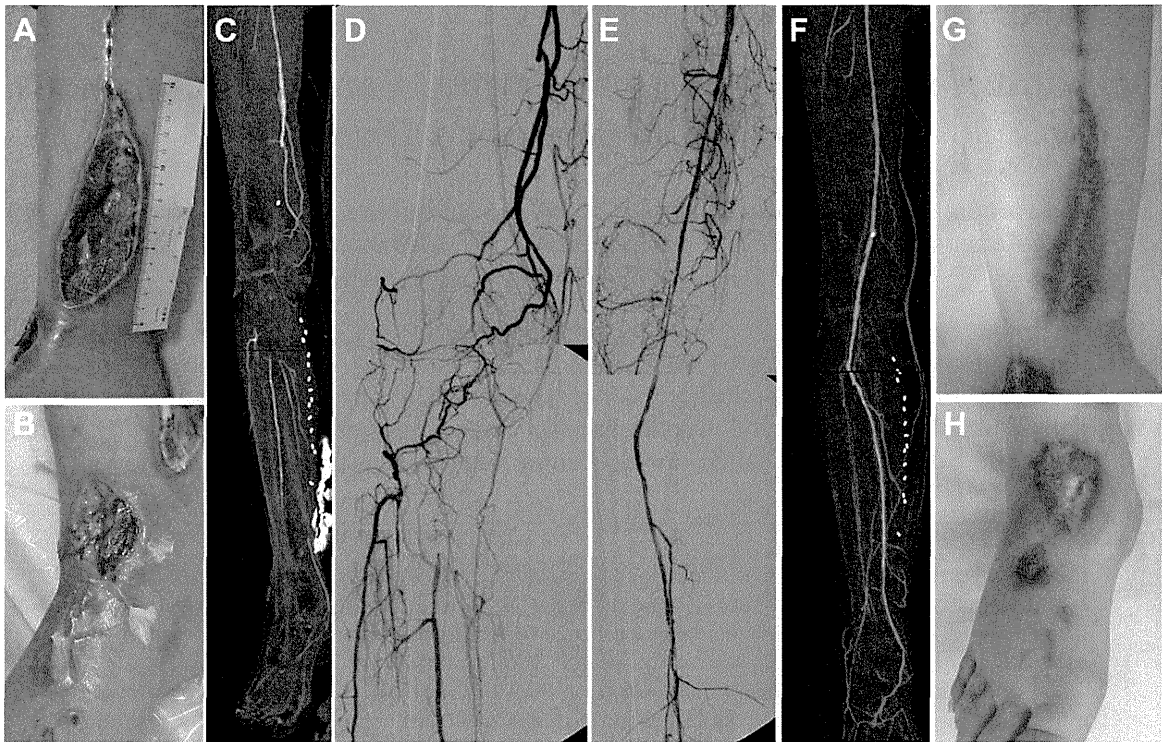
Figure ♦ A 38-year-old woman with infectious gangrene and extensive tissue loss on the (A) inside of the lower leg and (B) dorsum of the foot after early distal bypass failure. (C) CTA showing long total occlusion of the femoropopliteal segment, the proximal and mid segments in the posterior tibial artery, the tibioperoneal trunk, and the anterior tibial artery. (D) Angiography showing total occlusion of the femoropopliteal artery with collateral vessels. Final angiography (E) and (F) follow-up CTA showing the straight-line flow to the foot from the femoral to posterior tibial arteries. (G) Complete wound healing of the medial lower leg defect at 1 month; (H) the dorsal wound completely healed 5 months later.
